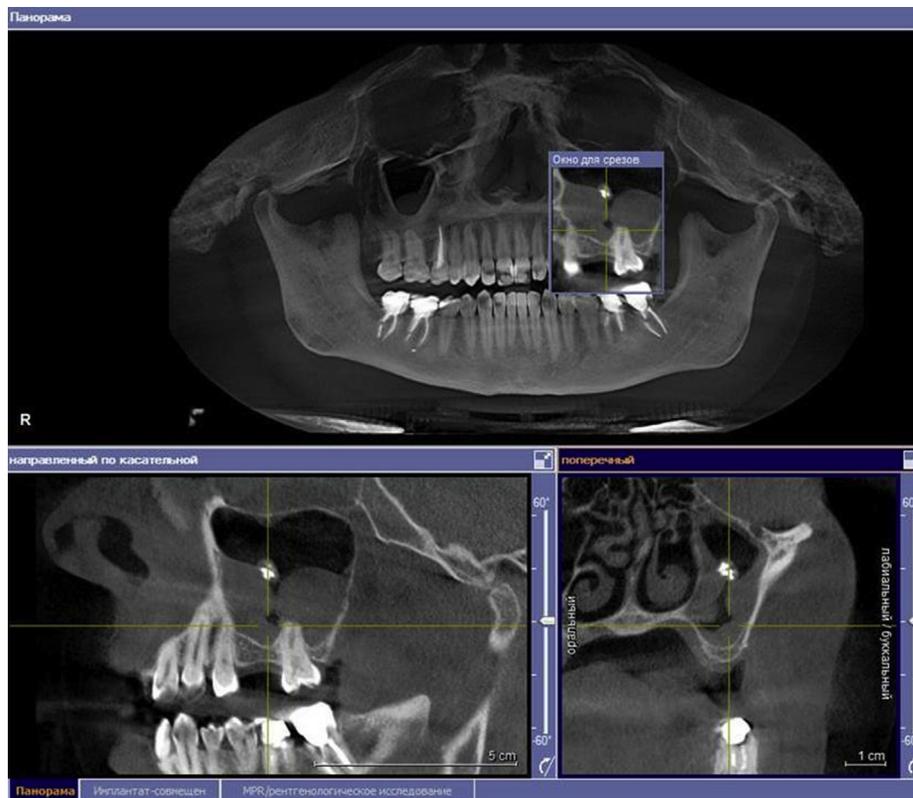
Preoperative CT scan of a patient with polyposoid sinusitis, showing foreign bodies in the maxillary sinus (filling material).
